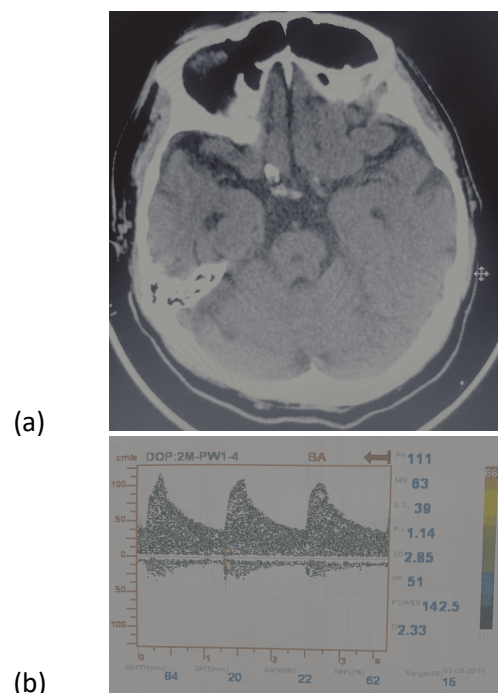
The pons stroke with severe basilar artery stenosis from trans cranial doppler examination
